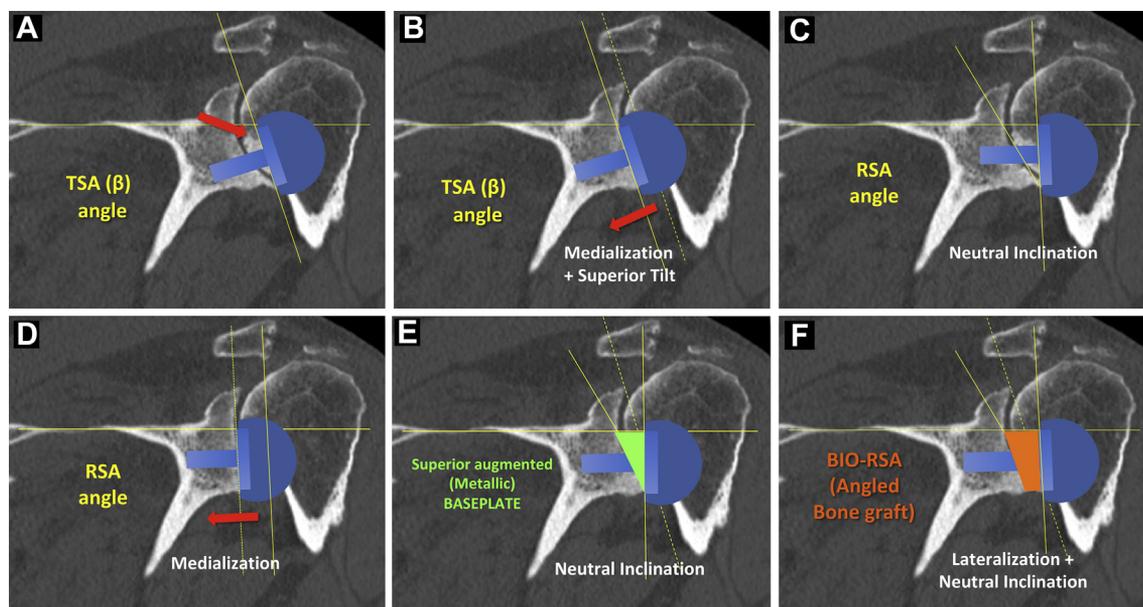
Preoperative 2-dimensional computed tomography templating in a patient with rotator cuff tear arthritis and Favard type E1 glenoid erosion: (A, B) Implantation of the baseplate according to the TSA (β) angle leads to superior tilt of the glenosphere. (C, D) To ensure neutral tilt of the glenoid component (ie, to correct the RSA angle), eccentric inferior reaming of the native glenoid is needed, but this leads to compromise of the bone stock and medialization of the glenosphere. (E, F) Compensating for the superior inclination of the inferior portion of the glenoid with metal (superior augmented metal baseplate) or bone graft allows correction of the RSA angle while avoiding medialization of the glenosphere. TSA, total shoulder arthroplasty; BIO-RSA, bony increased offset-reverse shoulder arthroplasty.
